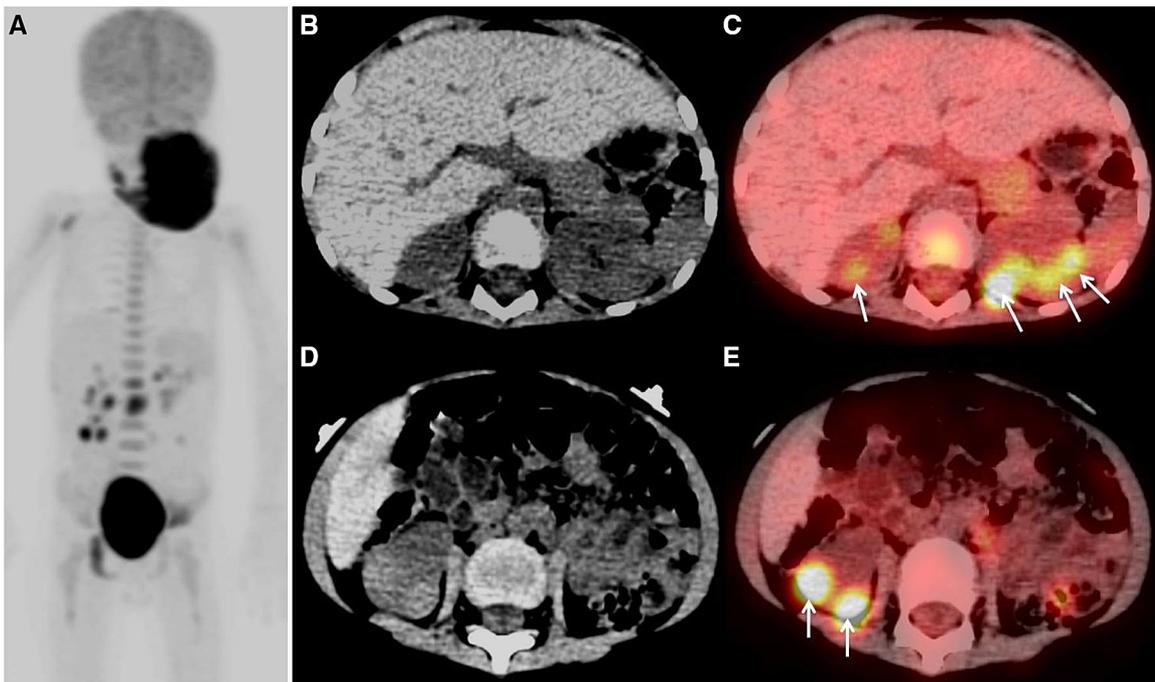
A–E Whole body Fluorine 18 Fluorodeoxyglucose (F-18 FDG) Positron emission tomography/computed tomography (PET/CT) scan of a 2-year-old child with Burkitt’s Lymphoma; whole body projection image A shows
